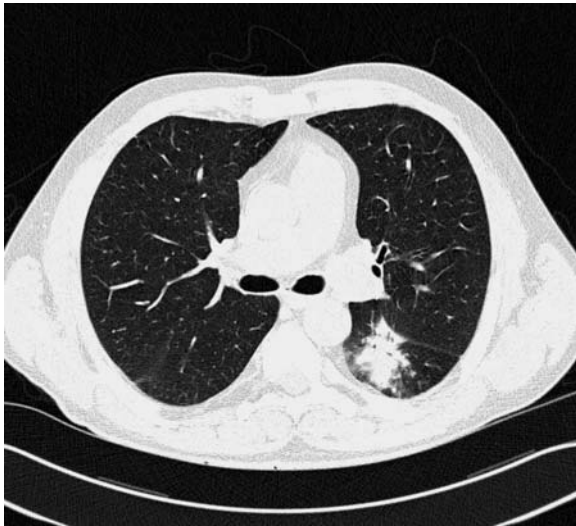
Invasive aspergillosis in a 55-year-old man with acute myeloid leukemia. Chest CT scan (collimation 12×0.75 mm) shows nodule with surrounding ground-glass attenuation (“CT halo sign”) in the superior segment of the left lower lobe
